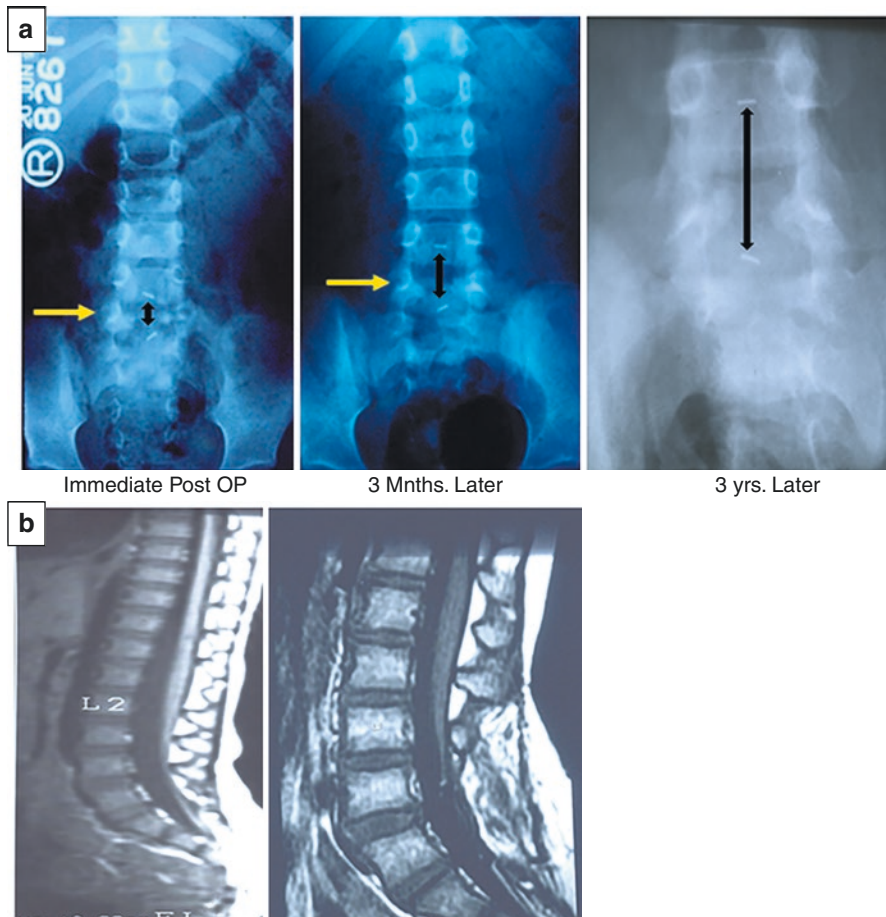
(a) Post-operative X Rays of the LS spine after cutting a filar lipoma. (b) Pre & Post-operative MRI-LS spine of same case. (a) Post-operative X rays of LS spine (AP view) showing the relative increase in the distance between the two liga clips over a period of time indicating adequate cord ascent. (b) Pre-operative & post-operative MRI LS spine (sagittal sections) showing complete division of the filar lipoma with relaxed end of filum which is unattached to the posterior dura
